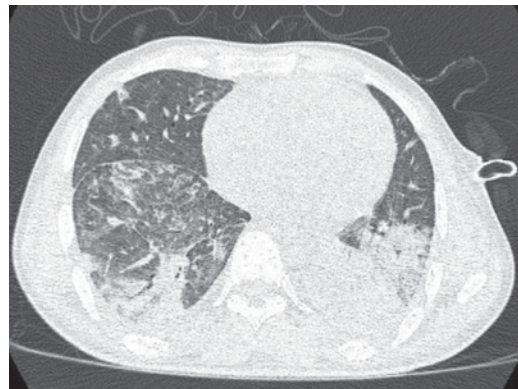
CT scan of chest showing bilateral pulmonary oedema & consolidation
